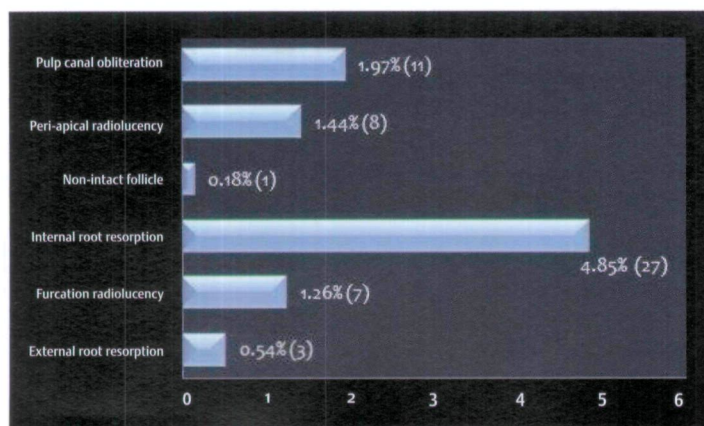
Distribution of radiographic failures.
